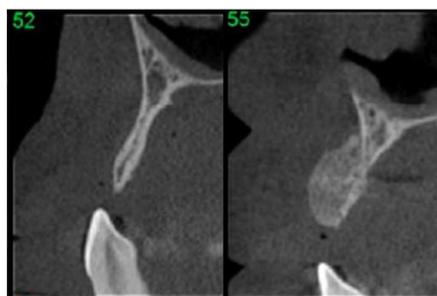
Pre- and post-operative CBCT. The extent of the regeneration is noteworthy.
